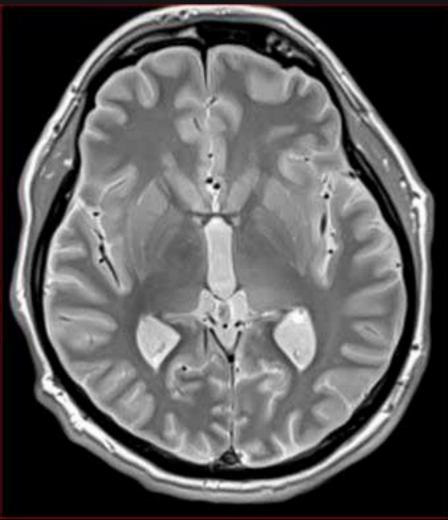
Preoperative 3T MRI protondensity image showing anatomical landmarks with high detail.
